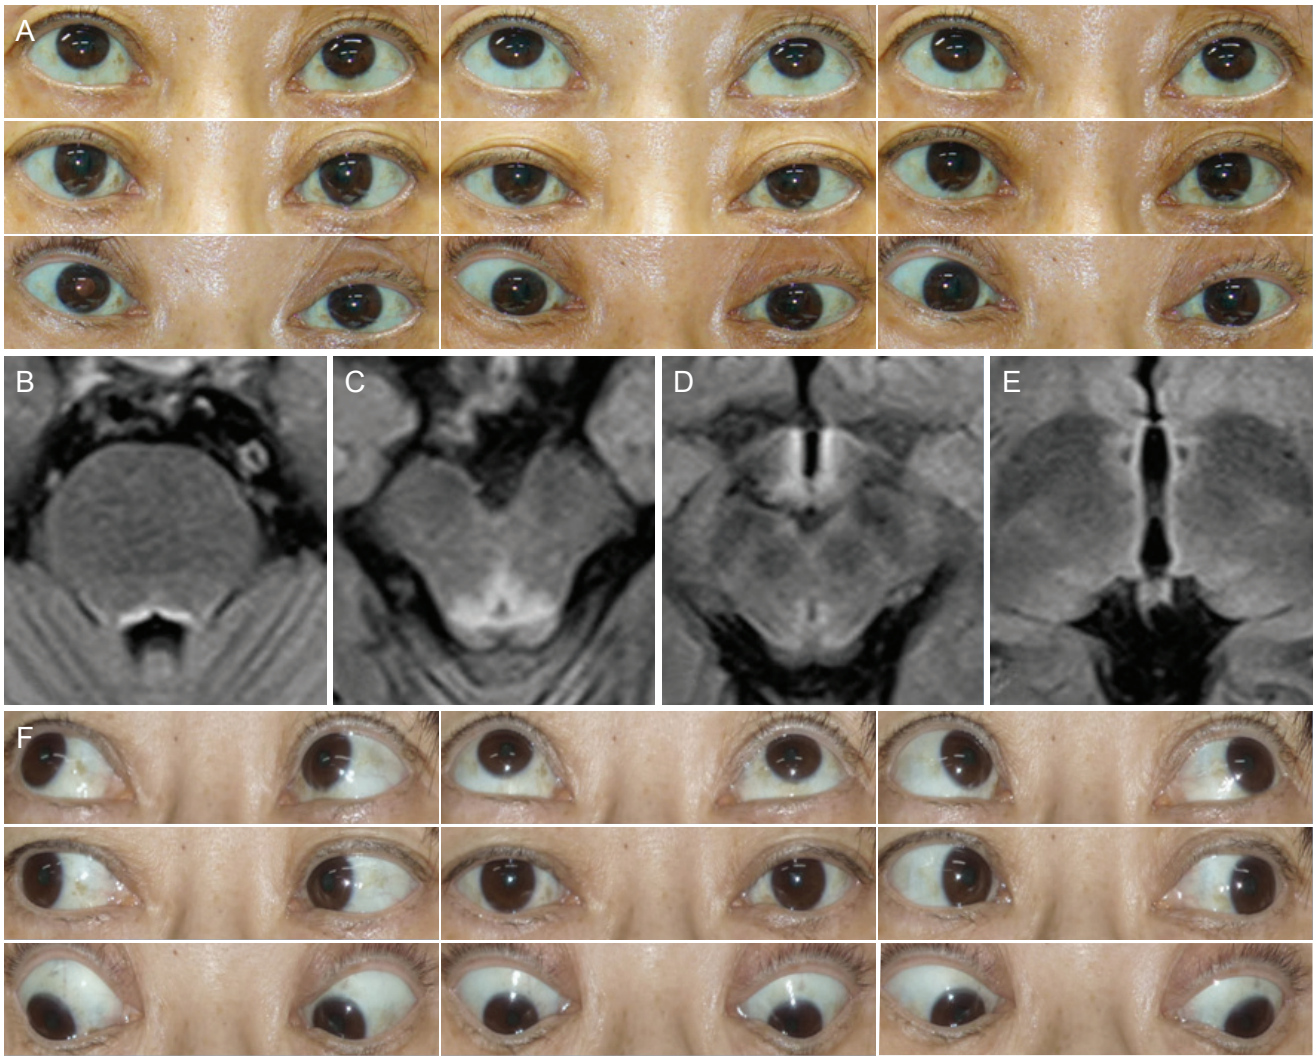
Images of the patient in nine diagnostic positions of gaze, demonstrating bilateral complete horizontal and downward gaze palsy (A). Fluid attenuated inversion recovery (FLAIR) images of the brain show high signal intensity at the bilateral tegmentum of the pons (B), periaqueductal region of the midbrain (C,D), and the medial thalamus (E). Images of the patient in nine diagnostic positions of gaze, demonstrating normal ocular alignment, without any limitation, at 1 month after administration of thiamine (F).
